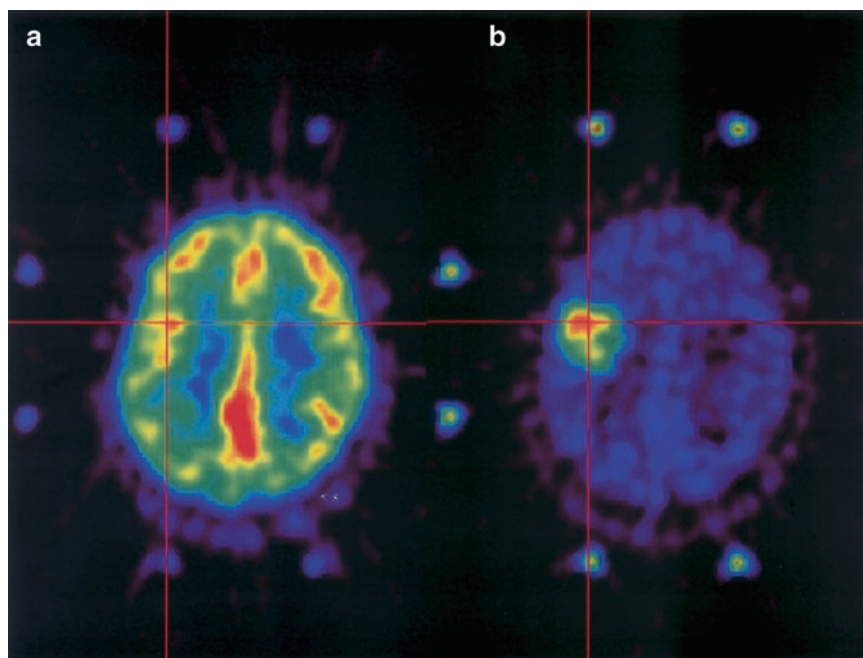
Stereotactic FDG-PET (a) and Met-PET (b) images in a glioblastoma located in the left fronto-rolandic cortical area. Tumor FDG uptake was equivalent to that of the surrounding grey matter and a target could not easily be defined on FDG-PET alone. Therefore, Met-PET was used for target selection
